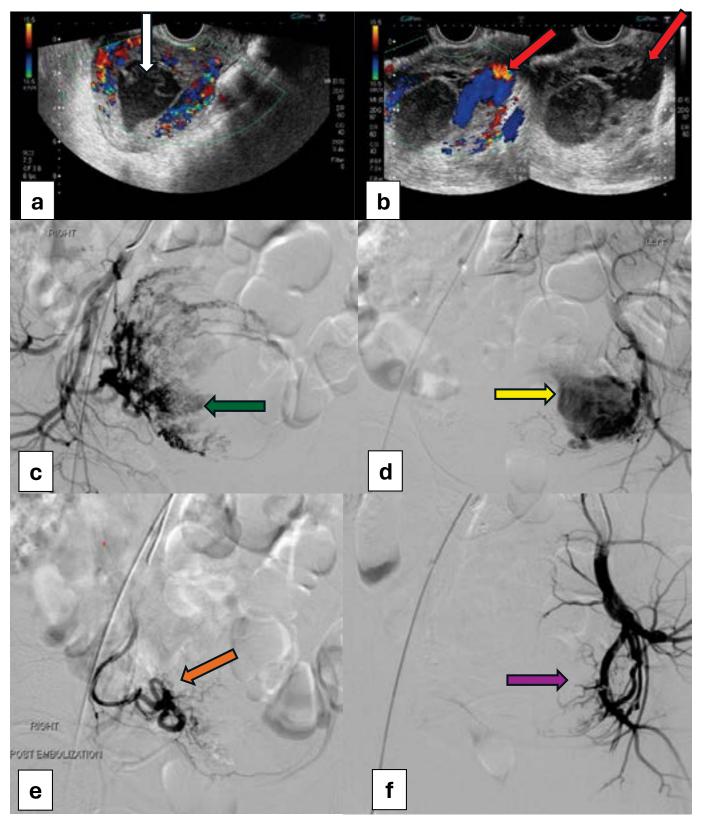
(a) Transvaginal grey and colour doppler images that show endometrial canal has an irregular gestational sac with internal haemorrhage (White arrow) with increased vascularity of myometrium. (b) An anechoic area is seen along the left lateral wall of myometrium showing turbulent flow on colour Doppler (Red arrow), suggesting AV malformation. (c) & (d) Right and left uterine artery pre angioembolization runs show large AVM supplied by the feeders from both uterine arteries and left ovarian artery (Green and Yellow arrows). (e) & (f) Right and left uterine artery post angioembolization runs show complete embolization of the vascular malformation (Orange and purple arrows).
